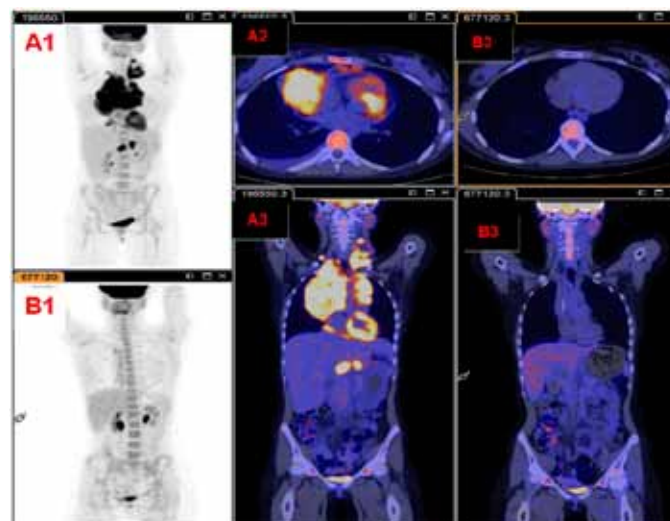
Comparison of initial staging PET/CT (Panels A1, A2, A3), scan showing non-FDG-avid pericardial effusion and the mediastinal mass, with a final PET/CT after six cycles of chemotherapy (Panels B1, B2, B3).
